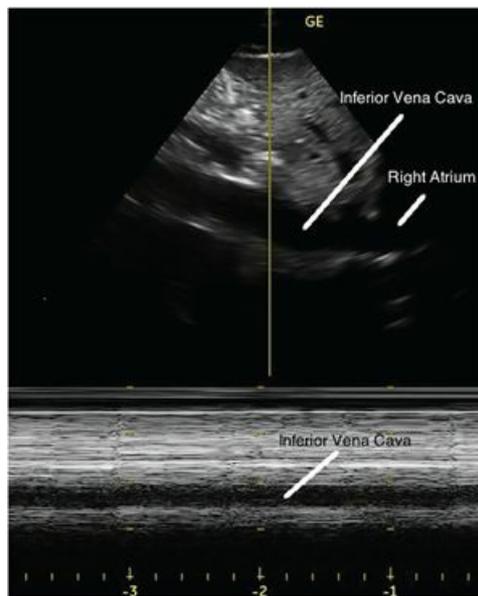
Ultrasound view of the inferior vena cava (IVC). The IVC can be assessed by either two-dimensional echo (top) or M-mode (bottom).
